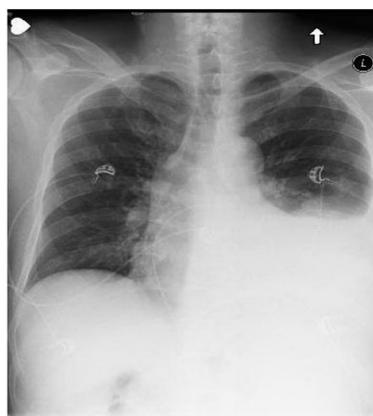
Chest x-ray shows left pleural effusion
